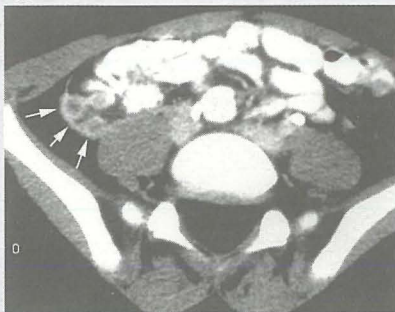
CT scan showing an inflamed appendix in cross-section measuring <7mm in diameter (arrows).
